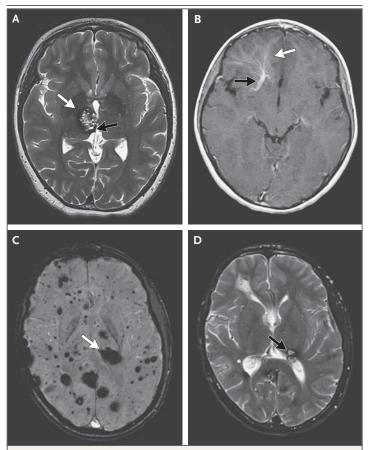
Characteristic Features of CCMs on MRI Studies.
